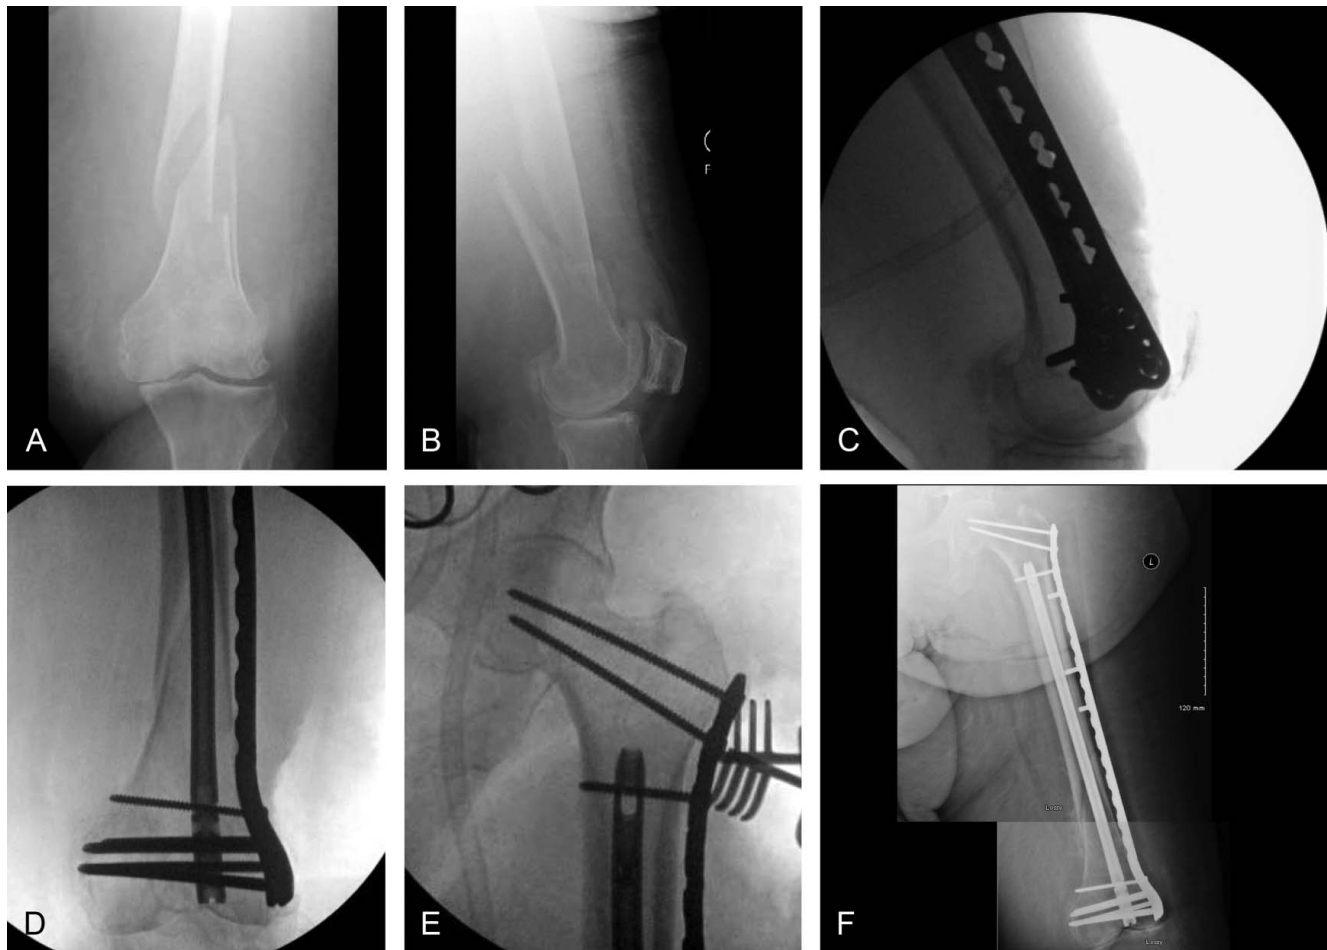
A–F, Patient is a morbidly obese 65-year-old woman, s/p twisting injury while getting out of bed and fell. A–B, AP and lateral radiographs revealed a distal femur, metaphyseal fracture with shaft extension in osteoporotic bone. Keeping in mind the pre-existing knee osteoarthritis, a midline, lateral parapatellar approach was used in preparation for potential future TKA. Similar to the previous case, a step-wise approach was performed to place the nail, pick, prepare, and plate the plate, (C–D) link the system distally and provide balanced, spanning fixation with (E) proximal prophylactic fixation. This patient was made immediately weight bearing as tolerated and continued to ambulate and heal, with bridging callus already seen at the (F) 6-week follow-up time point. The patient continued to do well and is now ambulating at home with a cane at 1-year follow-up.
